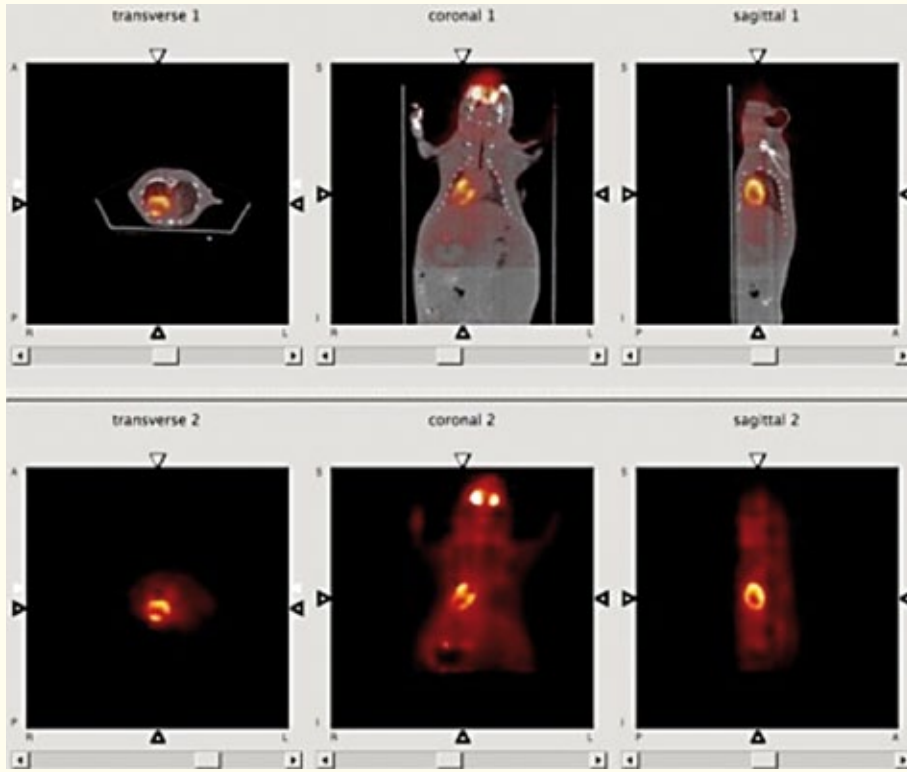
Typical imaging performance on one of the most recent preclinical examples (IRIS, raytest-IVISCAN). Top: PET/CT image obtained with the IRIS PET/CT scanner; bottom: PET image only (courtesy of Panetta D and Salvadori P, IFC-CNR, Pisa, 2013).
